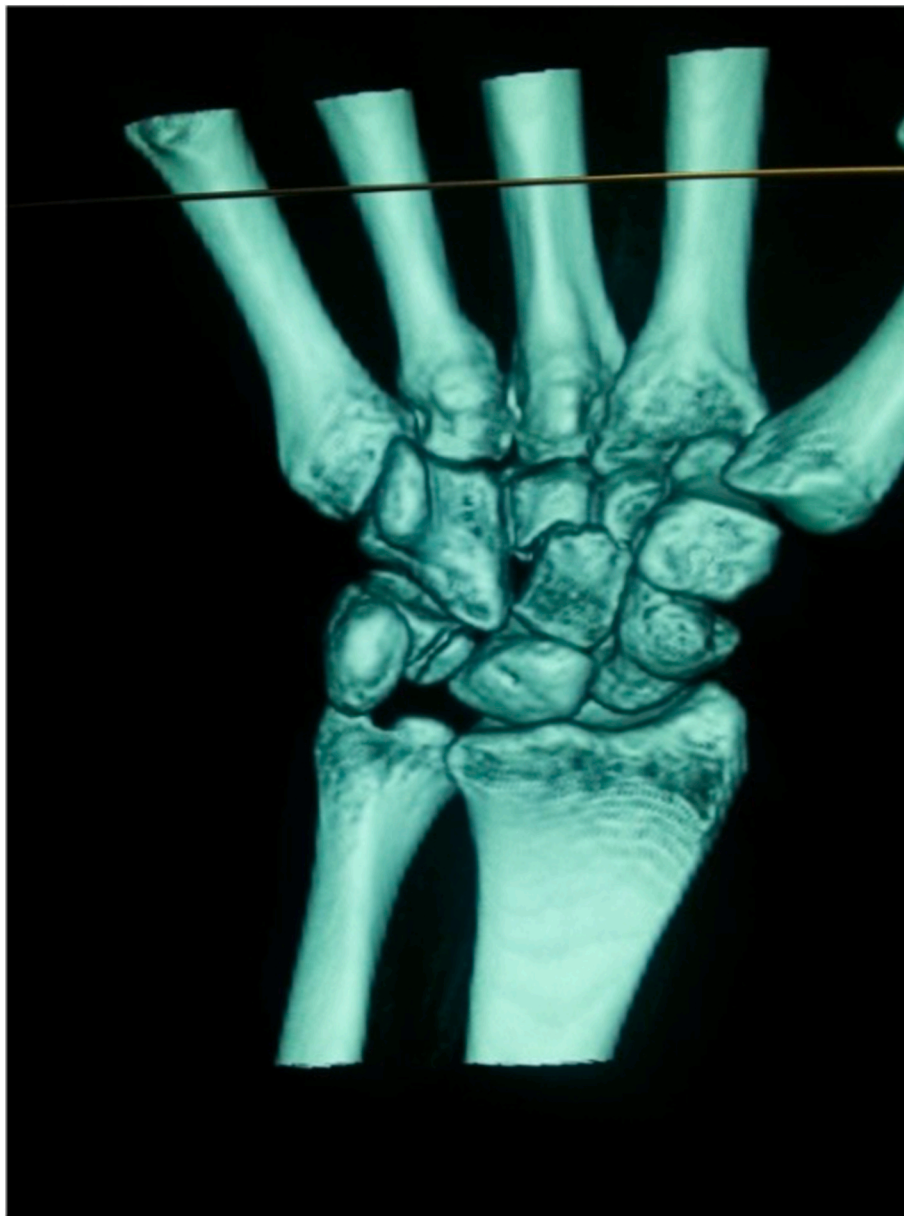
CT scan 3D reconstruction showing nonunion of capitate fracture
